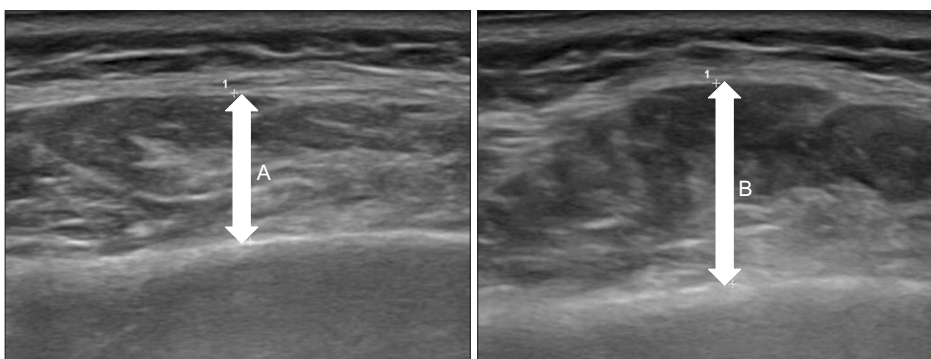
Masseter muscle imaging with an ultrasonic diagnostic equipment. A, masseter muscle thickness during rest; B, masseter muscle thickness during clenching; B-A, difference in masseter muscle displacement.
